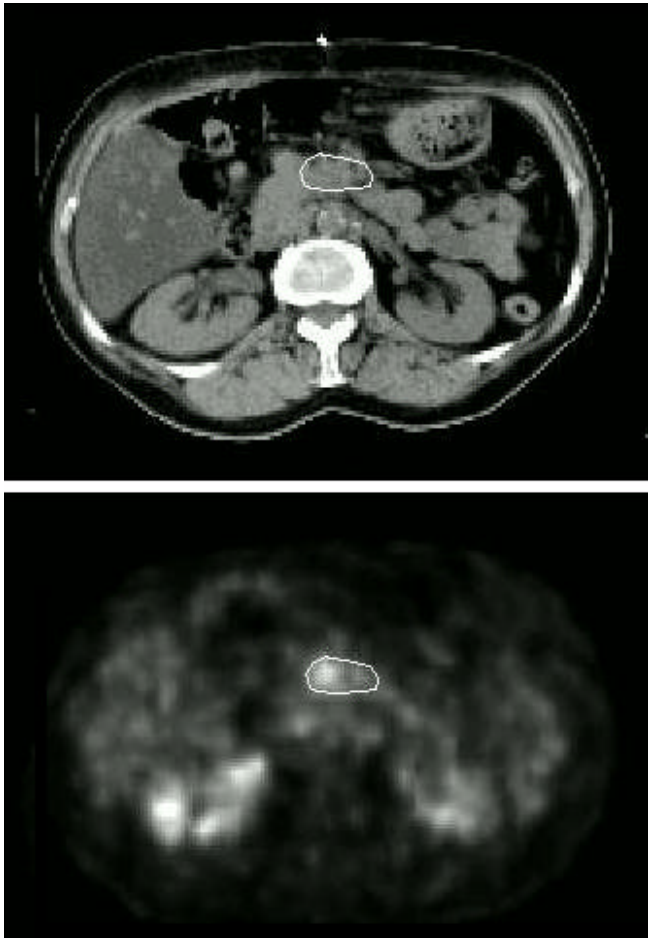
The contour of the pancreatic tumour drawn on two registered CT(up) and PET(down) slices. The hypermetabolic area, evidenced in PET image, guides the definition of the anatomical zone involved in the neoplastic process.
